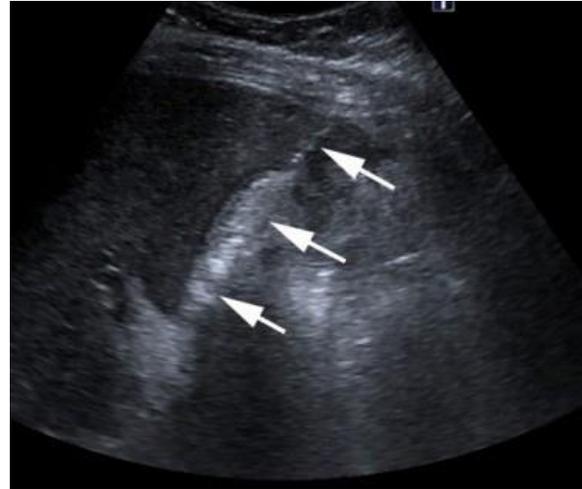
(b) : Ultrasound image shows percutain drainage catheter and decrease in gallbladder volume at first day control after cholecystostomy
